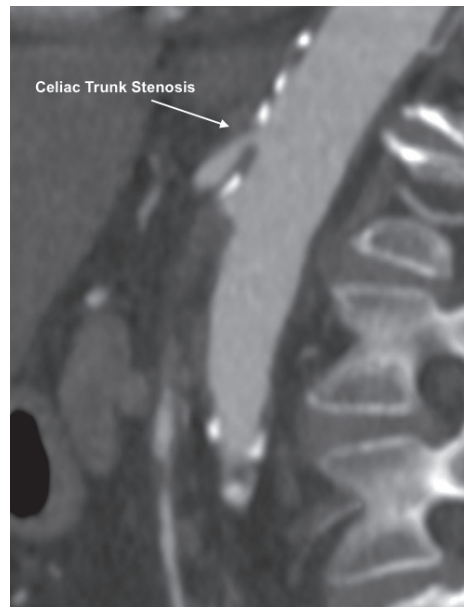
CT scan showing the celiac trunk stenosis
